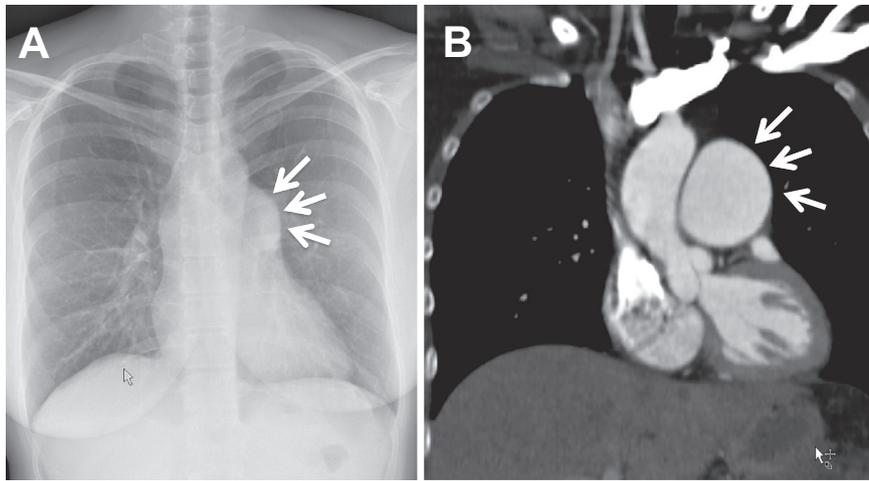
Chest X-ray (Panel A) of a patient with dilated main pulmonary artery (arrows) and corresponding chest computed tomography scan (Panel B).
